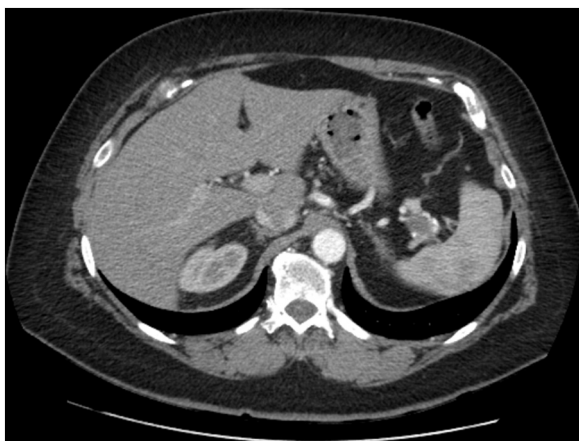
CT-scan of the abdomen showing a 2.0 cm diameter aneurysm of the splenic artery at the hilum of the spleen.
